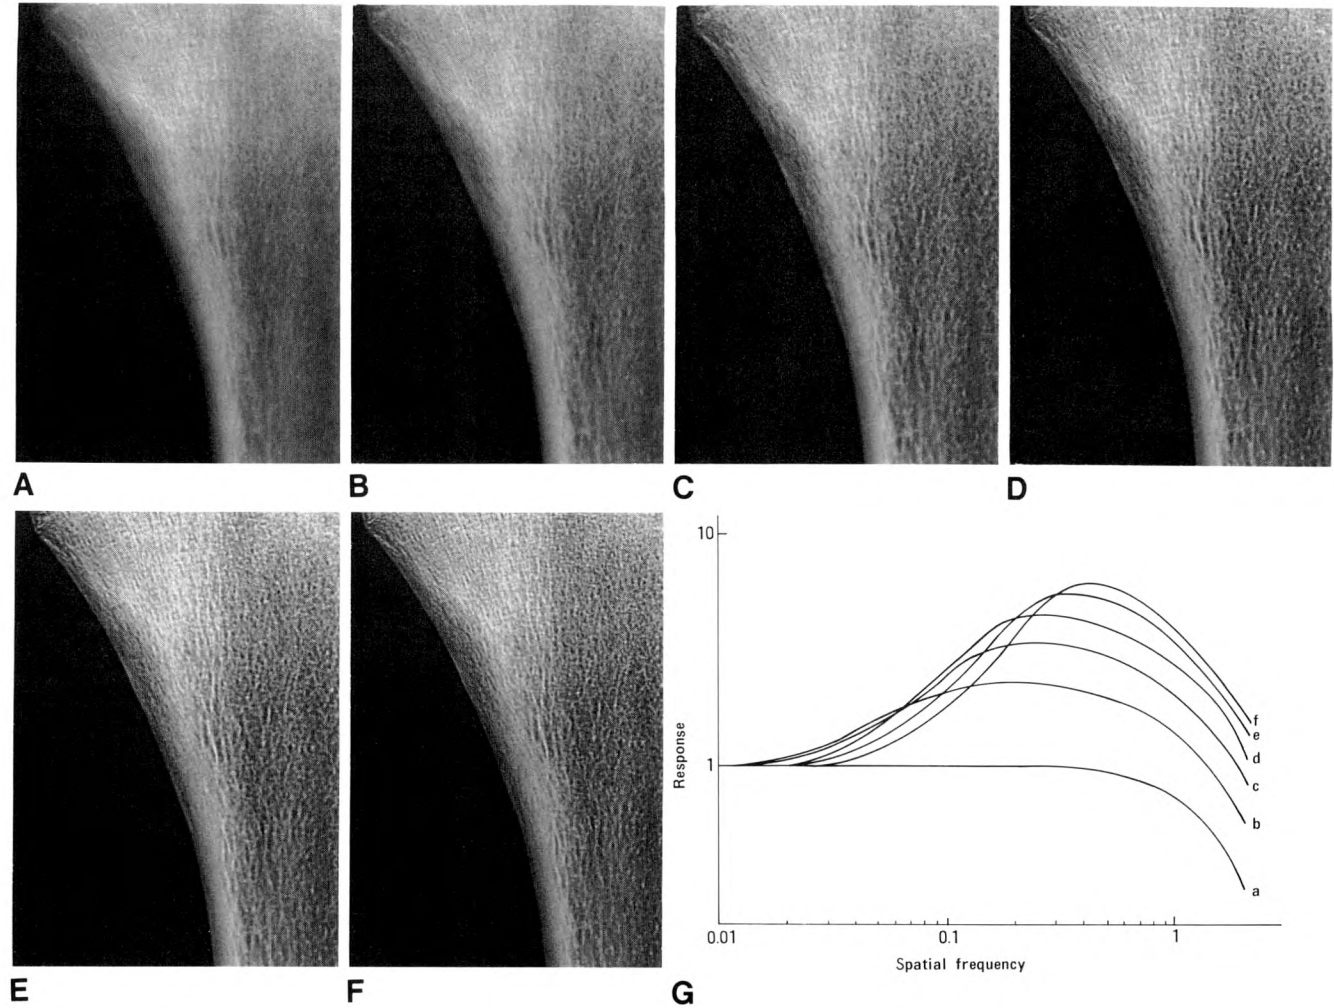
Effect of spatial frequency filtering with unsharp masking (A–F). Magnification ($\times 3$) of intracortical osteoid osteoma is displayed with different spatial frequency filters. The radiographic technical factors were 90 kVp, 20 mAs, and 150 cm focus-film distance with 1.0-mm focal spot size. Entrance skin exposure was 0.8 R (20.6 mC/kg).
